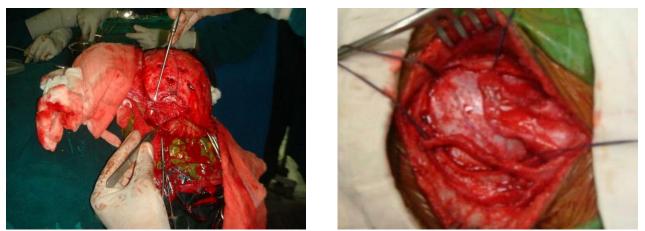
Ultrasound guided Superficial Temporal Artery Dissection.
